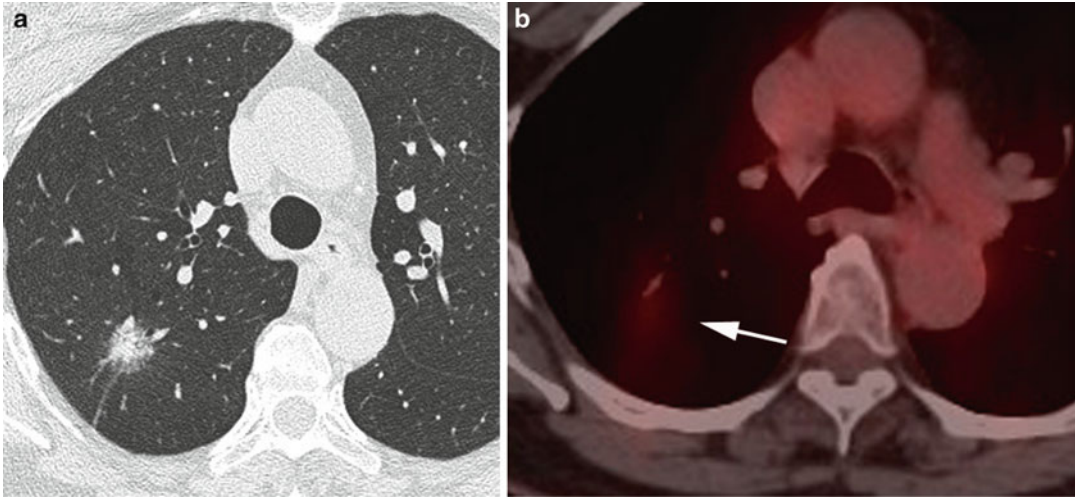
False-negative PET/CT. (a) Axial CT image reveals part-solid nodule in right upper lobe. (b) Fused PET/CT reveals faint uptake slightly above background
